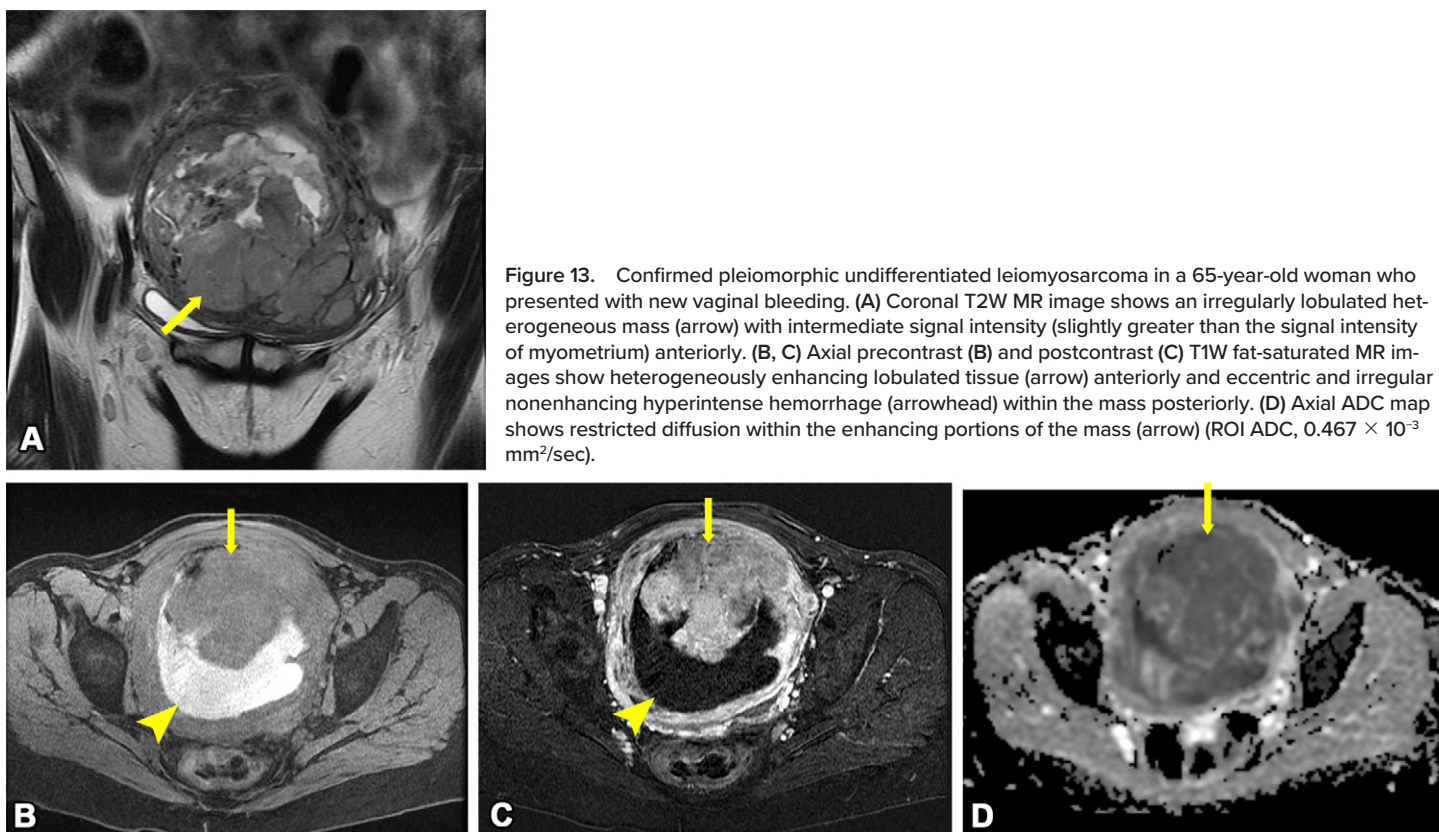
Confirmed pleiomorphic undifferentiated leiomyosarcoma in a 65-year-old woman who presented with new vaginal bleeding. (A) Coronal T2W MR image shows an irregularly lobulated heterogeneous mass (arrow) with intermediate signal intensity (slightly greater than the signal intensity of myometrium) anteriorly. (B, C) Axial precontrast (B) and postcontrast (C) T1W fat-saturated MR images show heterogeneously enhancing lobulated tissue (arrow) anteriorly and eccentric and irregular nonenhancing hyperintense hemorrhage (arrowhead) within the mass posteriorly. (D) Axial ADC map shows restricted diffusion within the enhancing portions of the mass (arrow) (ROI ADC, 0.467×10^{-3} mm²/sec).
